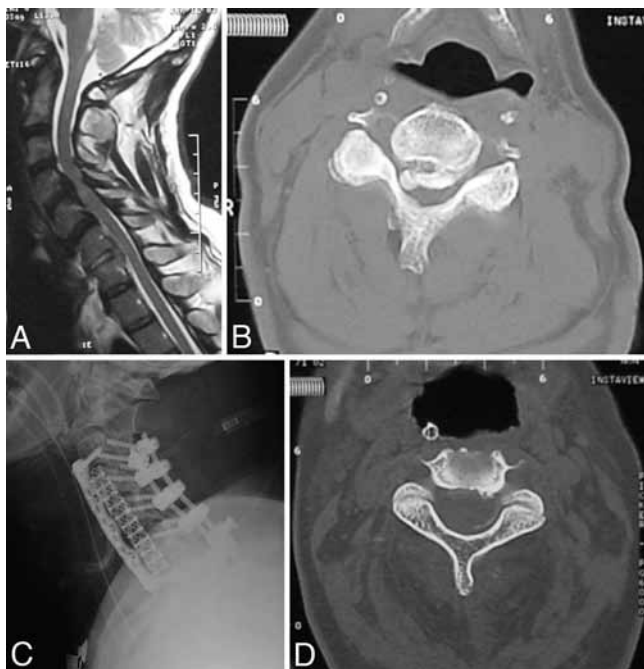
Images obtained in a 63-year-old Caucasian man who presented confined to a wheelchair with severe tetraparesis. Sagittal MR imaging (A) and axial CT (B) demonstrated severe stenosis to less than 4 mm at the widest (sagittal diameter) point. The patient underwent a combined anterior-posterior surgery for decompression and stabilization (C). An intraoperative dural tear resulted in an anterior neck pseudomeningocele noted on CT (D), which required subsequent surgery involving patching and the application of a fibrin sealant.
